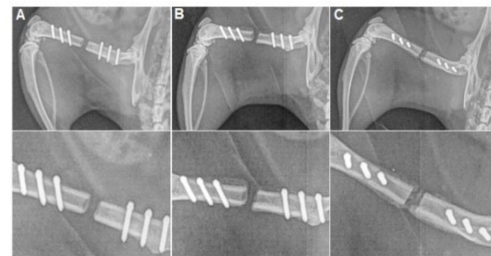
Representative radiographs of femoral defects 2 weeks post-surgery. (A) Empty, (B) Collagen sponge, (C) Collagen sponge + 1 µg BMP-2.
